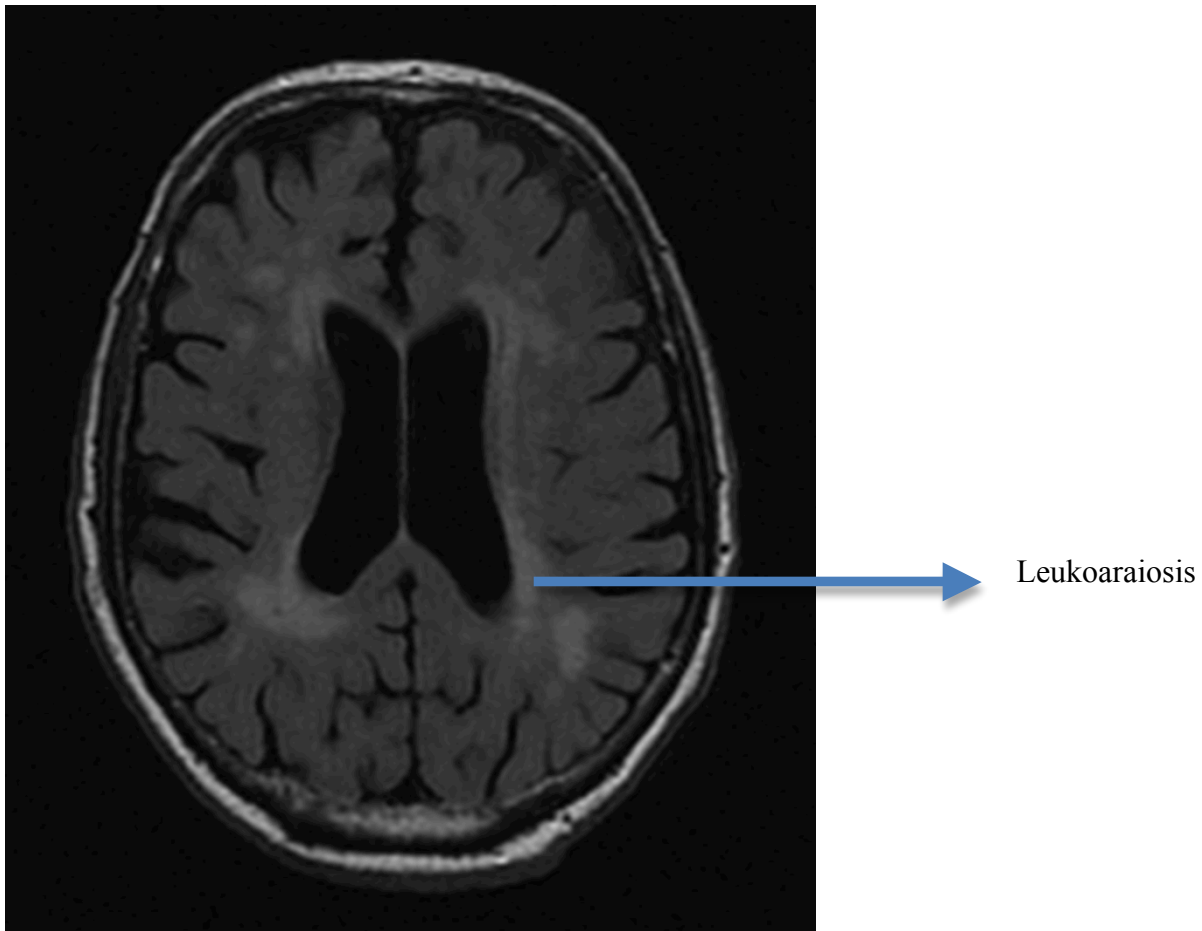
Leukoaraiosis, seen as bright areas in the white matter on T₂ weighted FLAIR imaging.
